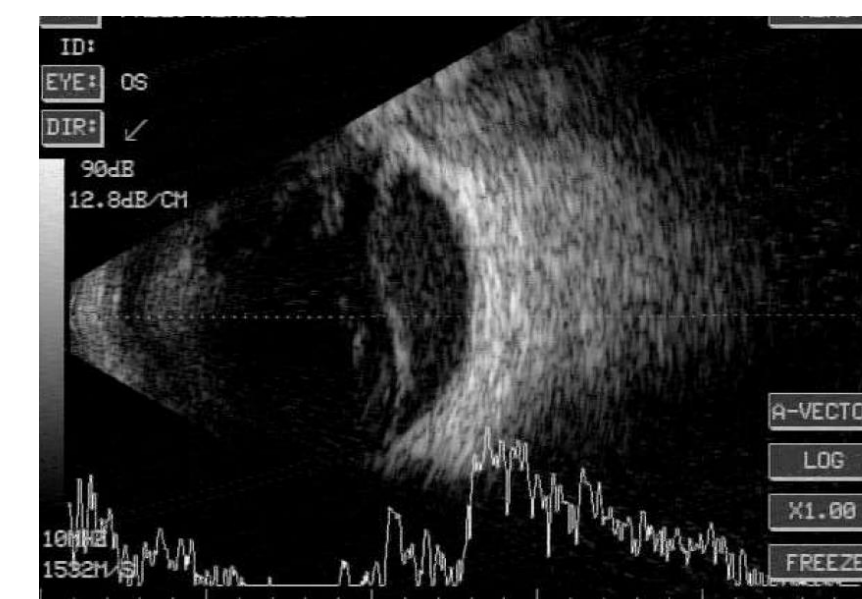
Ultrasound left eye
